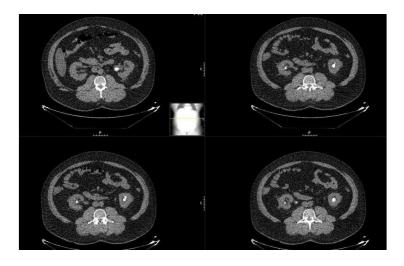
Abdominal CT scan performed in February 2019
